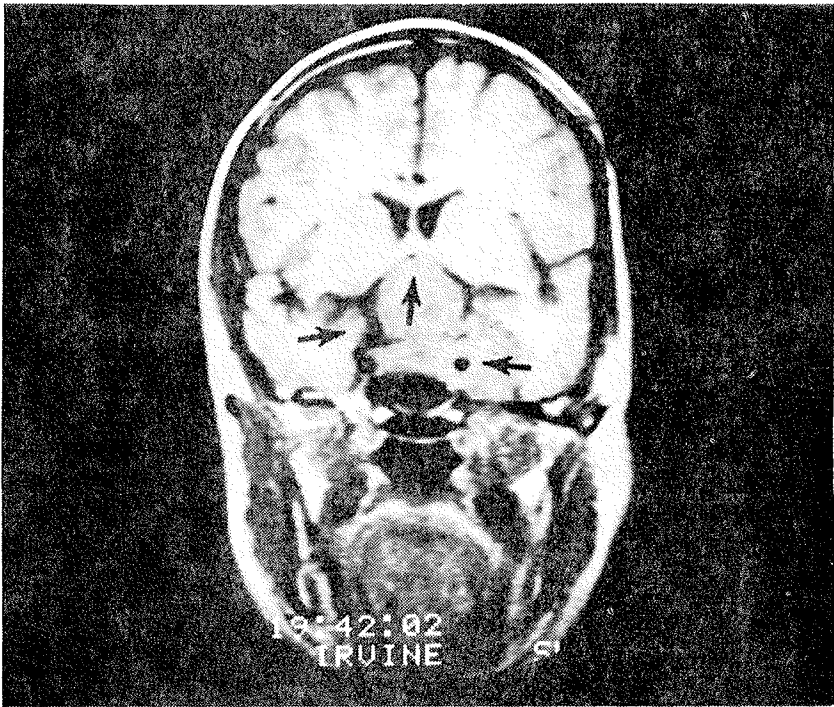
Intrasellar and Suprasellar Meningioma. Coronal MR image demonstrates intrasellar and suprasellar tumour. The suprasellar extension has obliterated the anterior third ventricle (vertical arrow). The supracavernous internal carotid artery (left arrow) is displaced laterally and the anterior cerebral arteries are displaced upward (vertical arrow). The cavernous internal carotid artery shows lateral displacement (left arrow).
